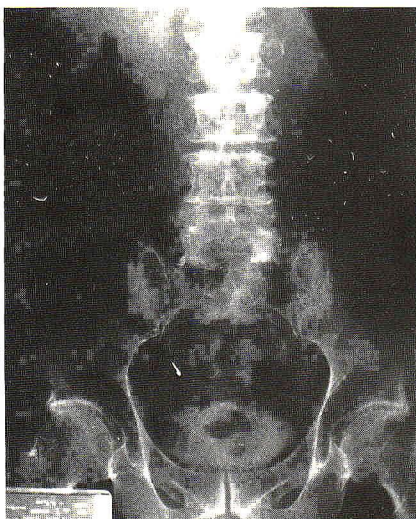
Plain film of abdomen showing soft-tissue mass in the upper abdomen.
